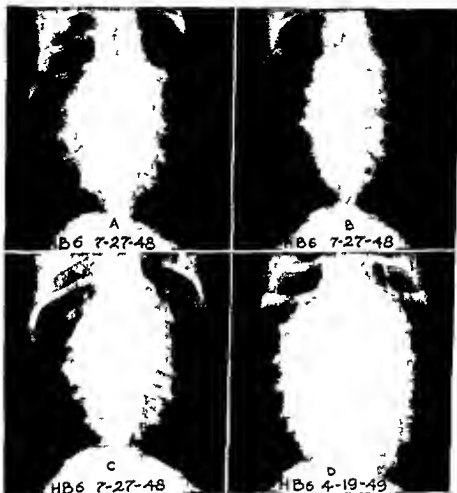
(HB).—The first effect of opening bilateral fistulas was to decrease the size of the heart (B) which was promptly restored to normal (C) by infusion of salt solution followed by gradual dilatation as shown in roentgenogram (D) taken nine months later.
